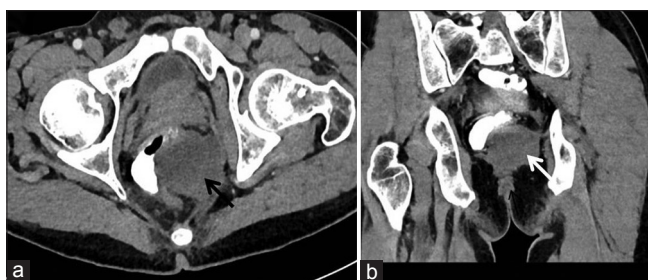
(a and b) Posttreatment imaging. Axial and coronal reformatted computed tomography images showing significant reduction in size, attenuation, and enhancement of the rectal gastrointestinal stromal tumor suggestive of partial response
